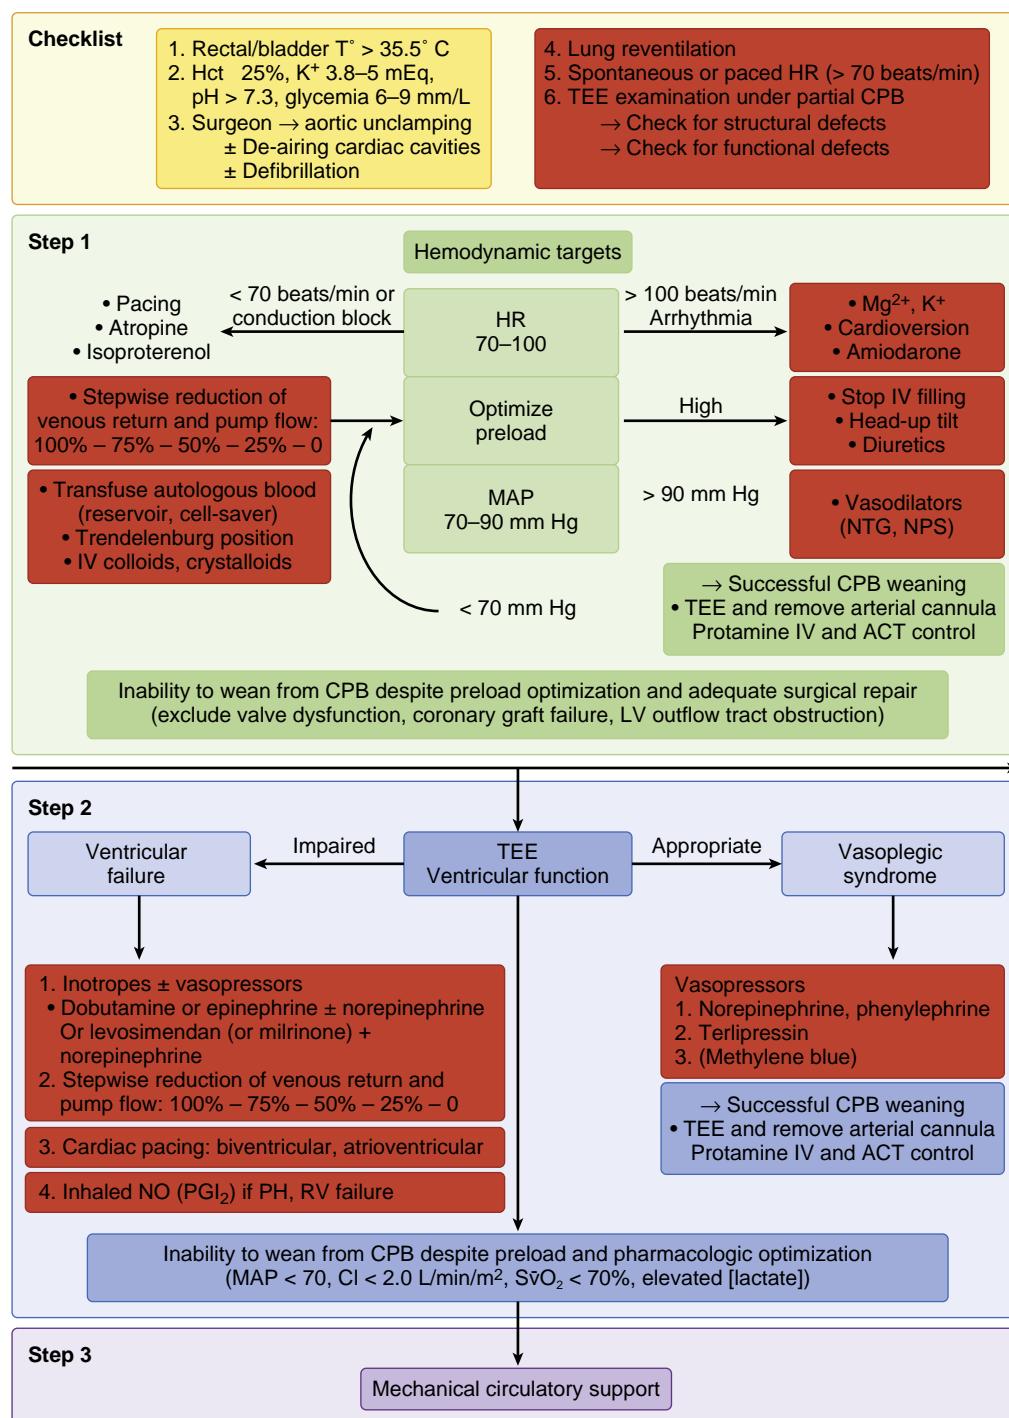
Algorithm for weaning from cardiopulmonary bypass (CPB). ACT, Activated clotting time; Hct, hematocrit; HR, heart rate; IV, intravenous; K^+ , potassium; LV, left ventricular; MAP, mean arterial pressure; Mg^{2+} , magnesium; NO, nitric oxide; NPS, sodium nitroprusside; NTG, nitroglycerin; PGI_2 , prostacyclin; PH, pulmonary hypertension; RV, right ventricular; SvO_2 , mixed venous oxygen saturation; TEE, transesophageal echocardiography. (From Licker M, Diaper J, Cartier V, et al. Clinical review: management of weaning from cardiopulmonary bypass. *Ann Card Anaesth*. 2012;15:206–223.)
